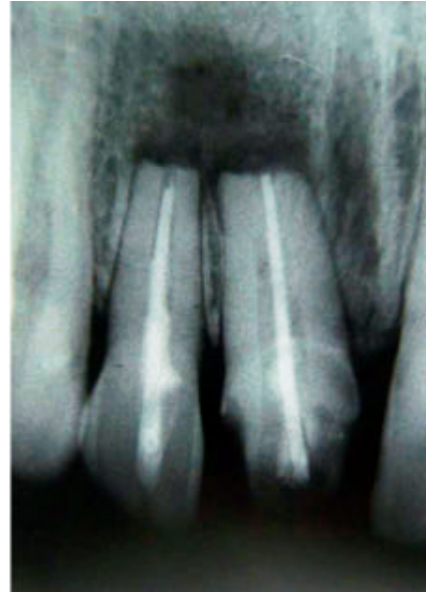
Preoperative radiograph showing bone loss in relation to 21 and 22
